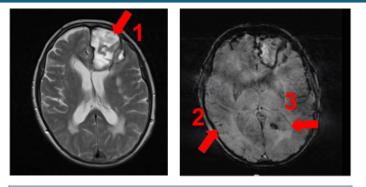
MRI T2 and SWI images showing: 1. Left frontal intra-parenchimal bleeding; 2. Lobar microbleeds; 3. Signs of hemosiderosis.
